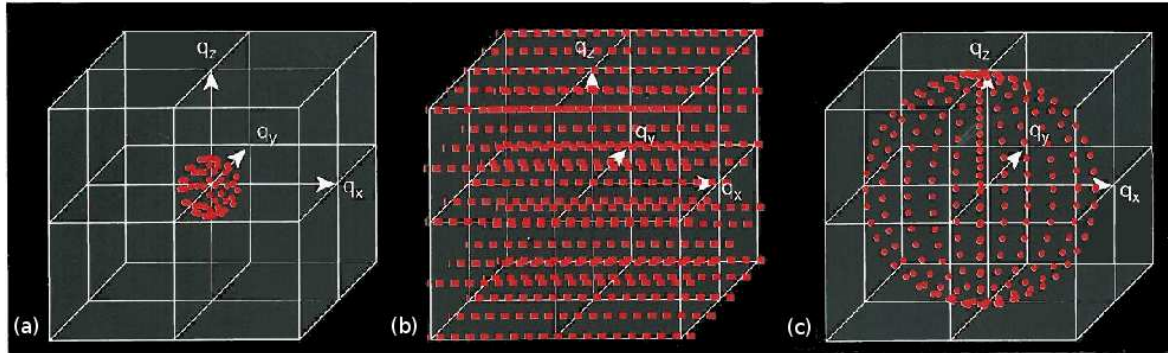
Three different sampling schemes for diffusion MRI. (a) DTI , (b) DSI and (c) QBI (image reproduced from [92]).
